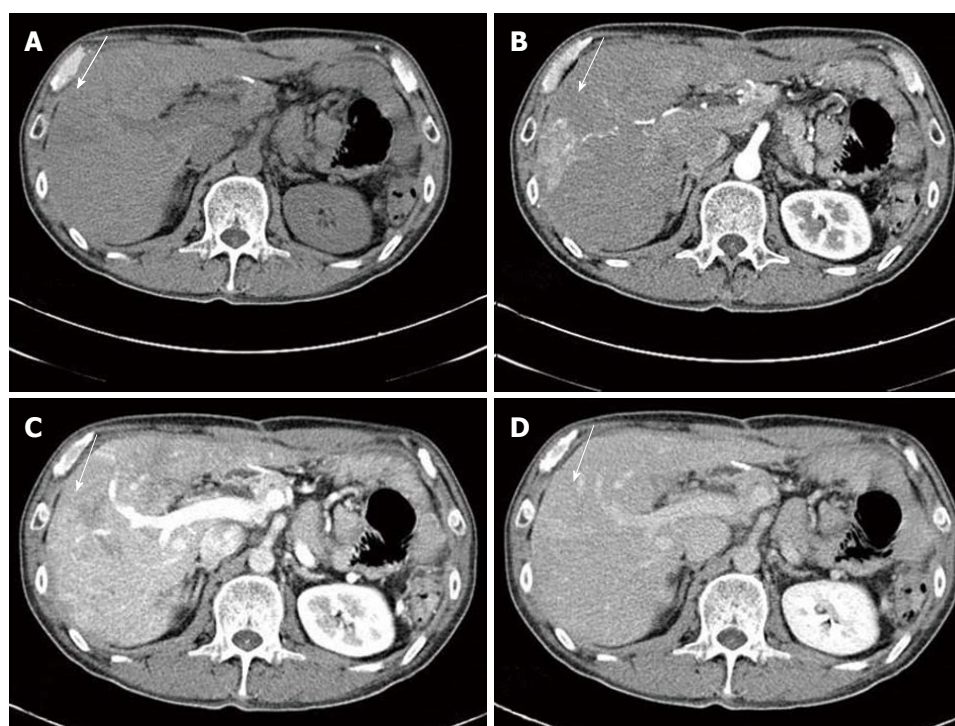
After total six cycle of chemotherapy (capecitabine and oxaliplatin), dynamic computed tomography showed an arterial enhanced mass like lesion. A: Pre-enhanced image; B: Arterial phase image; C: Portal phase image; D: Delayed phase image.
